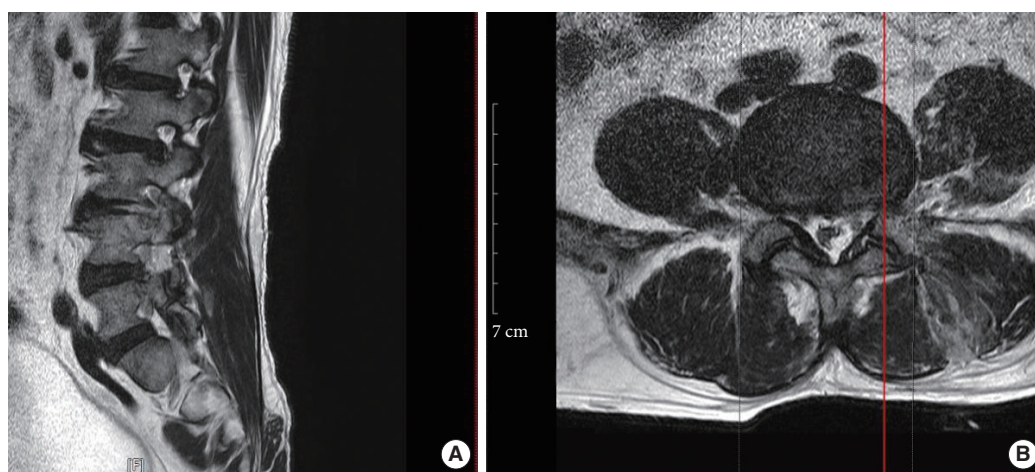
A T2-weighted postoperative magnetic resonance imaging sagittal (A) and axial (B) slice showing adequate discectomy of the left L3–4 far lateral disc.
